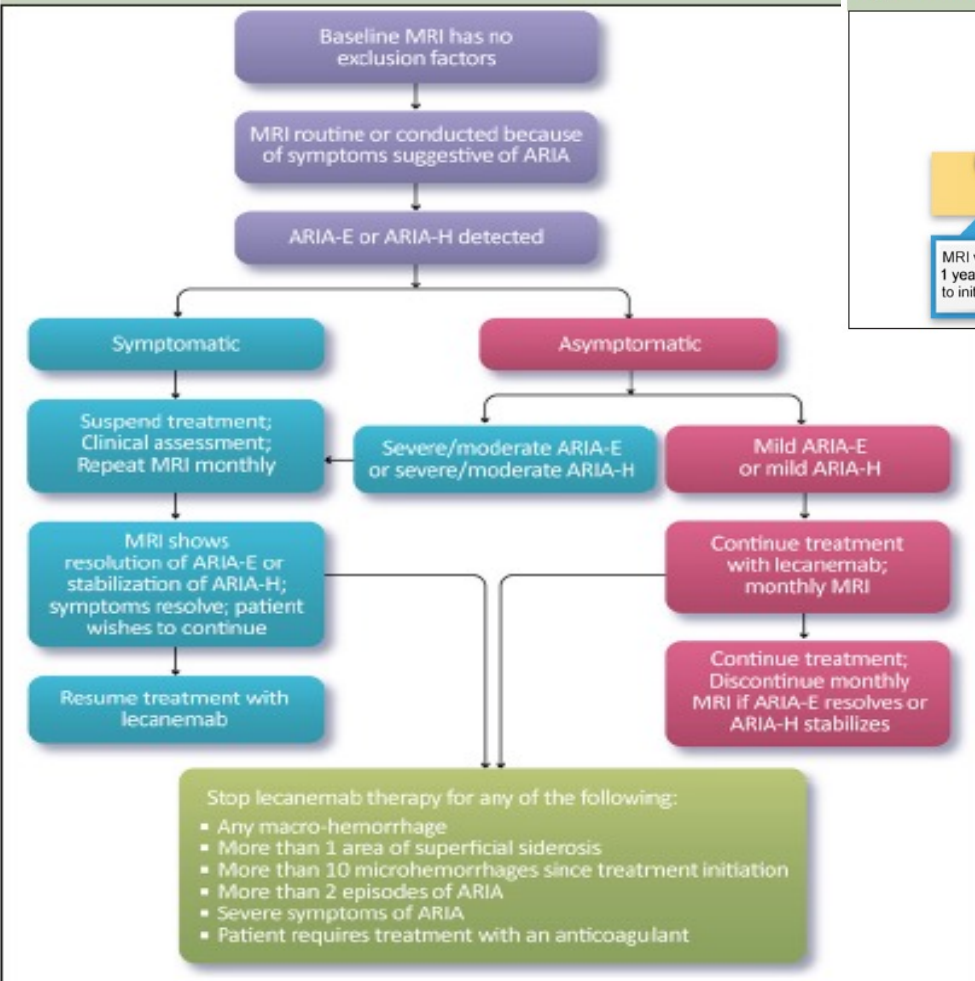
MRI monitoring for lecanemab
